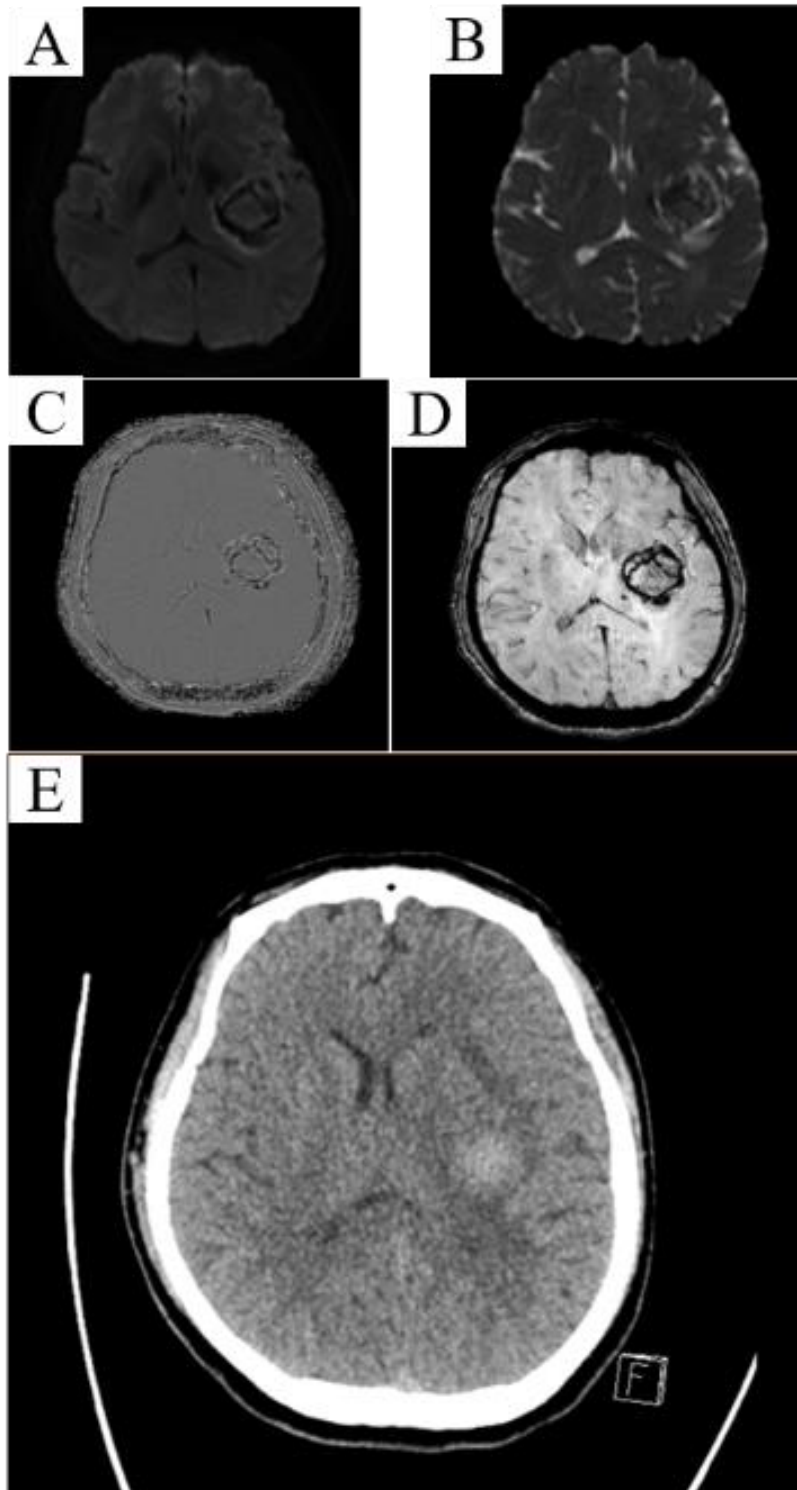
DWI shows area of hypointensity with surrounding hyperintensity rim (A) and corresponding Apparent Diffusion Coefficient (ADC) shows surrounding hyperintensity rim with heterogenous hypointensities centrally (B). The SWI with phase images (C, D) confirms presence of haemorrhage in the left basal ganglia. The CT scan (E) done within few hours of MRI shows presence of haemorrhage in the left basal ganglia.
